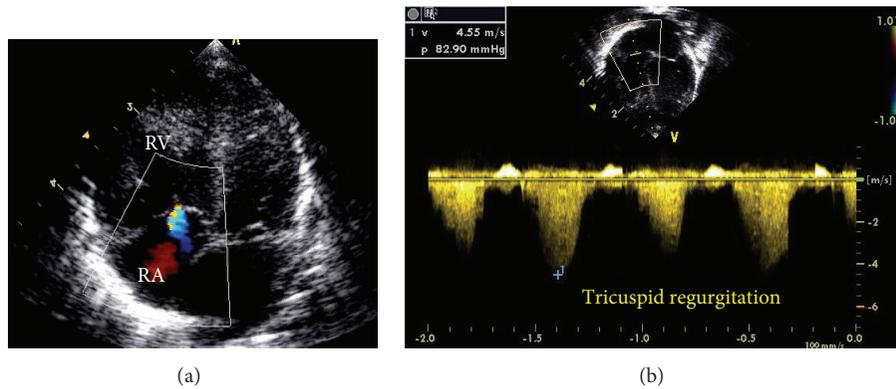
Newborn under invasive mechanical ventilation for hypoxemia in the first day of life. Apical view showing tricuspid regurgitation on color Doppler in blue (a) and on continuous wave Doppler (b). RV-RA gradient of 82 mmHg and the pulmonary artery systolic pressure is estimated at 92 mmHg (RV-RA gradient pressure added to the RA pressure).
